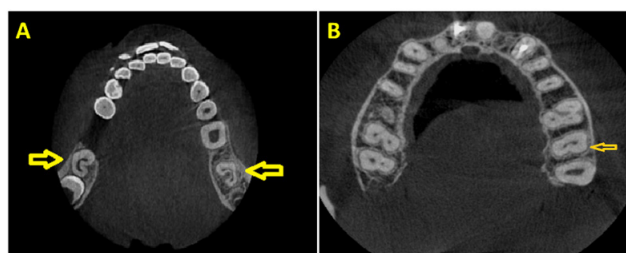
A: Axial CBCT section of a C-shaped canal of a mandibular second molar; B: Axial CBCT section of a C-shaped canal of a maxillary second molar
